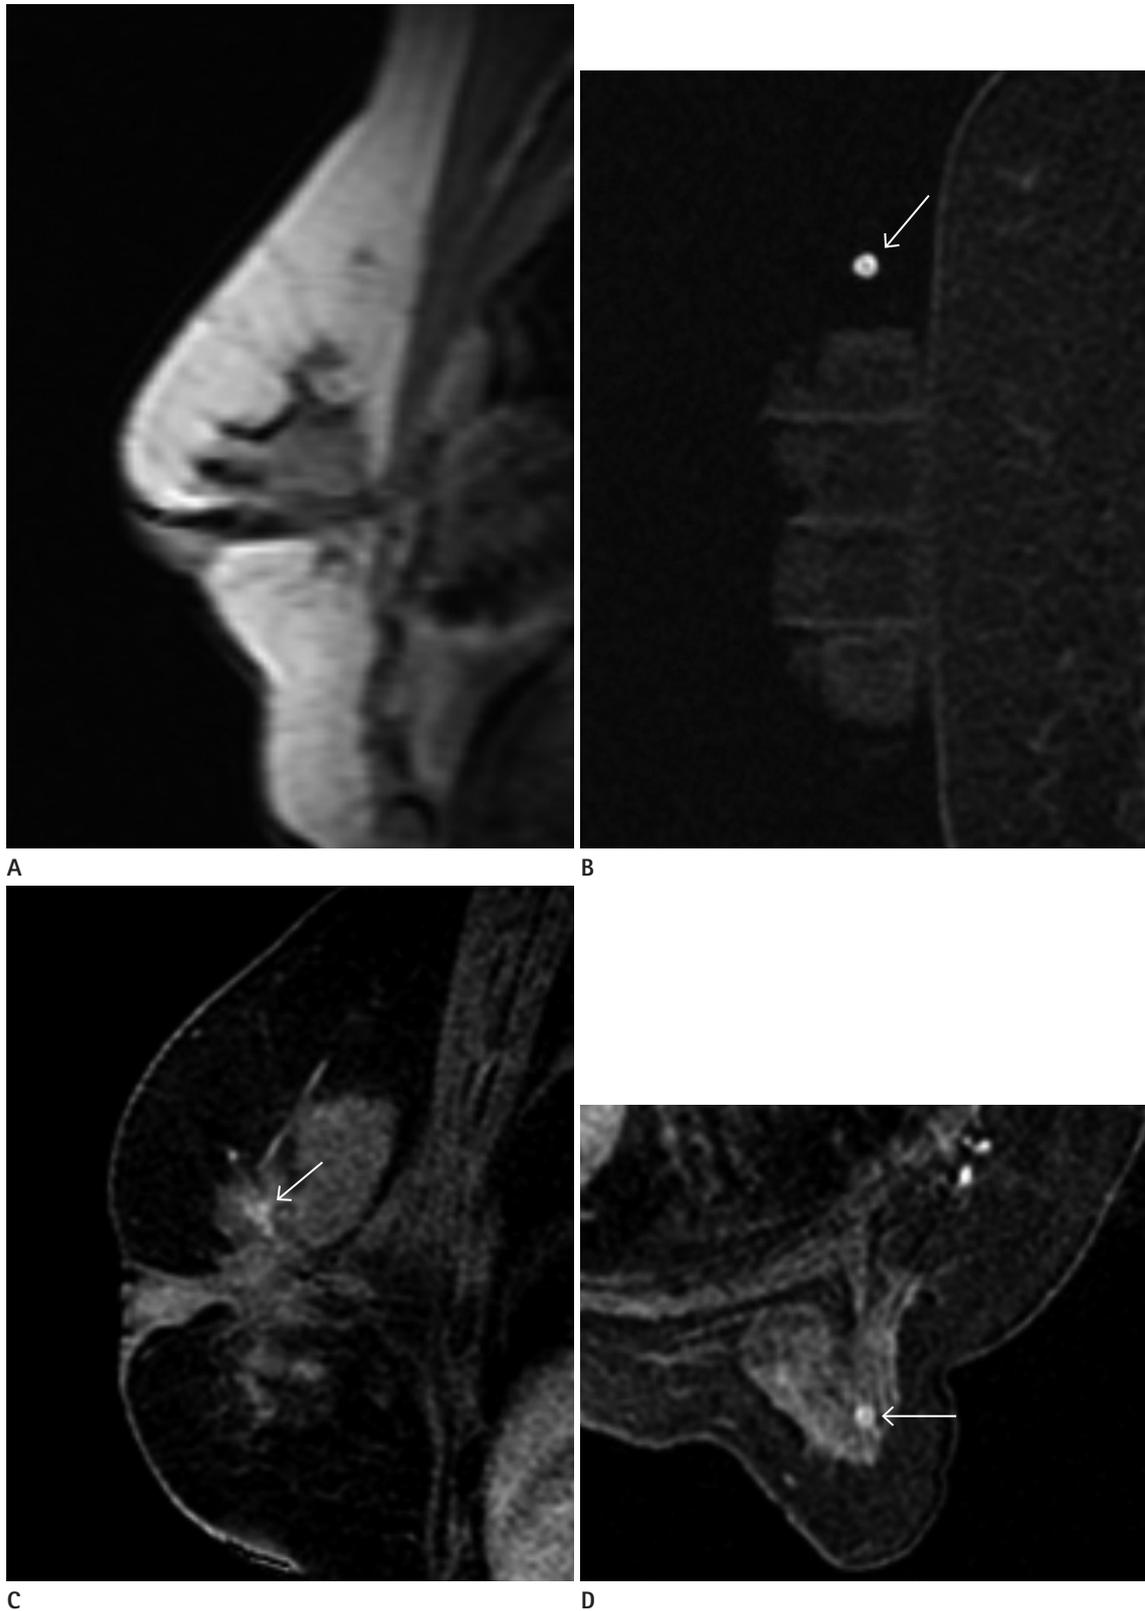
MRI-guided VAB procedure. After localizing image (A), precontrast images with fiducial marker (arrow) (B) are obtained. Sagittal and axial postcontrast images (C, D) are obtained to identify target location (arrow). VAB = vacuum assisted biopsy
